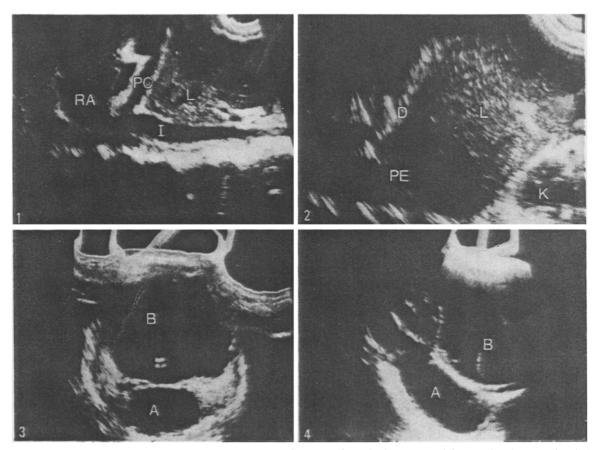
Ultrasonograms (Case 5). (1) Midline, longitudinal section through the upper abdomen showing a pericardial effusion. (2) Longitudinal section five cm to the right of the midline through the upper abdomen showing a pleural effusion. (3) Transverse section two cm above the public showing a pelvic abscess. (4) Midline longitudinal section through the lower abdomen showing a pelvic abscess. L = Liver: I = Inferior vena cava: PC = Pericardial effusion: RA = Right artium: D = Diaphragm: PE = Pleural effusion: K = Kidney: B = Bladder A = Pelvic abscess (By courtesy of Dr. P. Warner, Department of Diagnostic Ultrasound, Western Infirmary, Glasgow)
